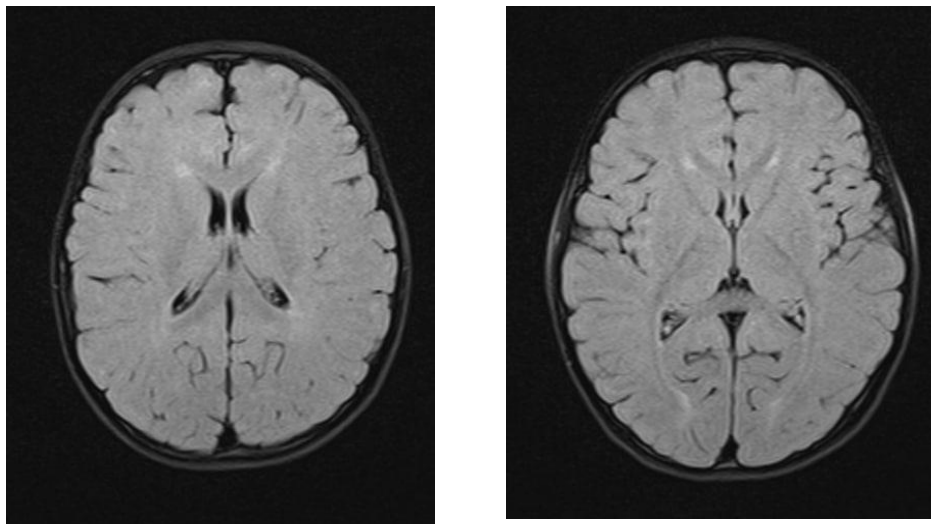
MRI Brain 2022/09/11
